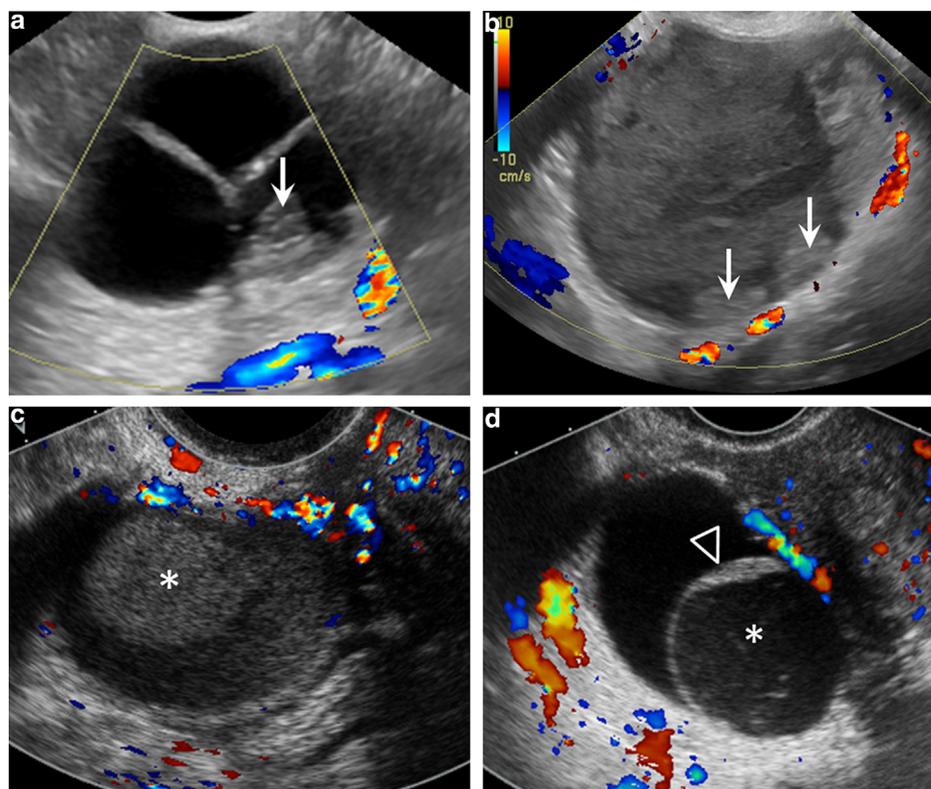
a: Gray scale and color Doppler ultrasound image of a partially cystic adnexal lesion with internal septations and a nodule, which does not have any internal color Doppler flow (arrow). The lack of color Doppler flow makes this lesion indeterminate on US; b: Gray scale and color Doppler ultrasound image of an adnexal lesion with internal heterogeneous echoes, and nodular areas along the posterior wall which lacks color Doppler flow (arrows). The presence of avascular solid nodules along the posterior wall makes this lesion indeterminate on ultrasound; c: Gray scale and color Doppler ultrasound image of a partially cystic adnexal lesion with internal homogeneous low level echoes and a spherical hyperechoic area (asterisk) with no posterior acoustic shadowing. This appearance is atypical of a dermoid because of the lack of posterior acoustic shadowing adjacent to the hyperechoic area; d: Gray scale and color Doppler ultrasound image of a partially cystic adnexal lesion, with simple fluid in a portion of the lesion and homogenous low level echoes in a portion (asterisk), separated by an irregularly thickened septations which lacks color Doppler flow (arrowhead). This appearance is atypical of a hemorrhagic cyst because of the avascular irregular thickened septation.
